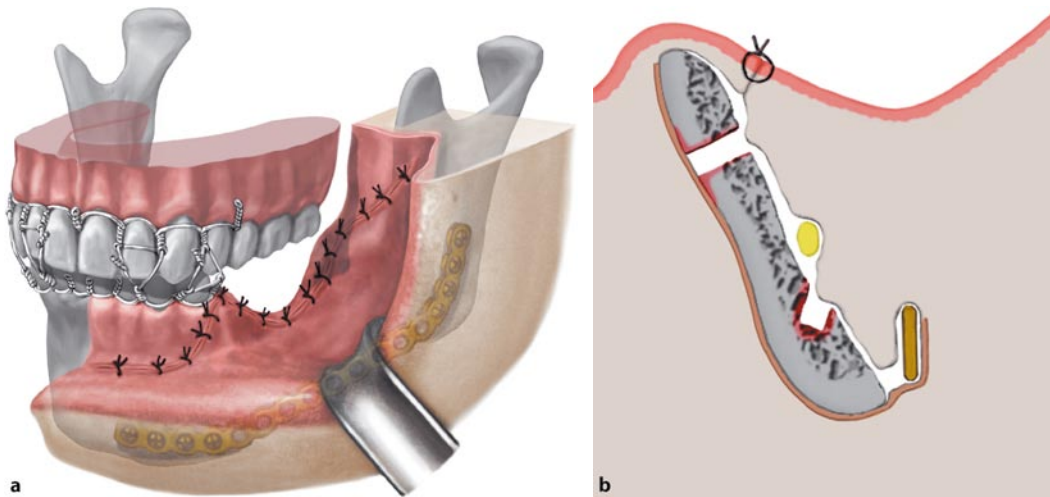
Maxillary–mandibular fixation may be performed if additional stabilization and immobilization is required. Postoperative orthopantomography of a patient with extensive secondary chronic osteomyelitis of the left mandible after surgical decortication is shown in c (case report 6, Chap. 12): the maxillary–mandibular fixation for 6 weeks with wire stents was additionally performed for sufficient stabilization and immobilization of the operated left mandible to ensure healing without complication c see next page
